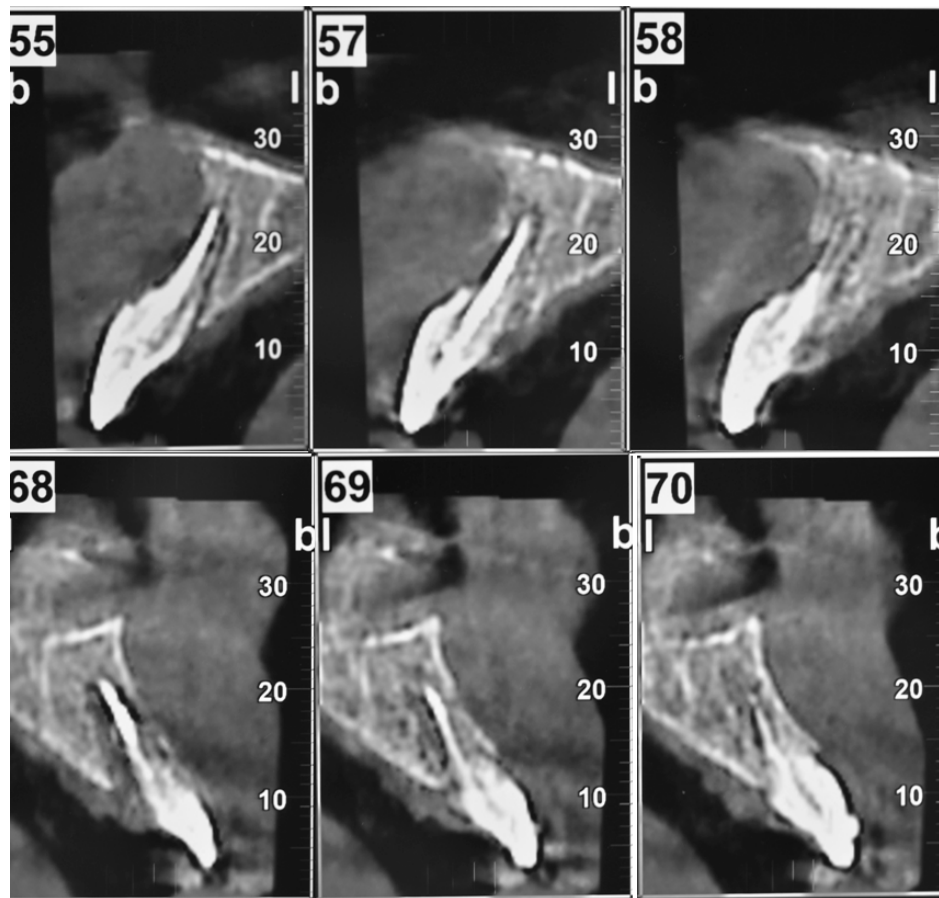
Series of parasagittal images from cone beam computed tomography (CBCT) of the two central incisors after 9 months of follow-up (13 December 2018); upper row tooth 11, lower row tooth 21.
